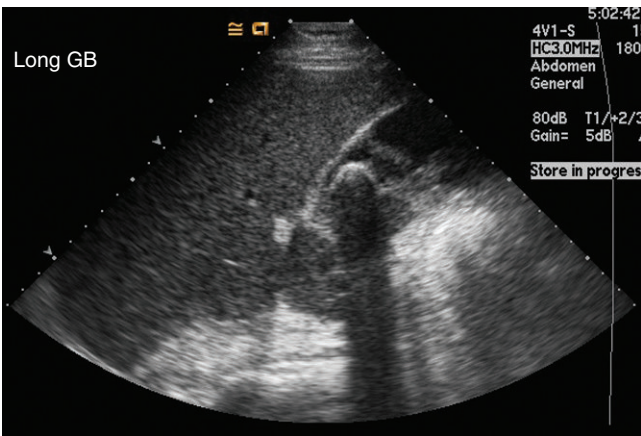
Ultrasound image shows classic features of a large gallstone, including highly reflective anterior surface and posterior acoustic shadowing.
